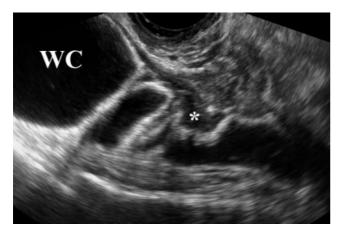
Rectal water contrast transvaginal ultrasonographic image showing a rectal endometriotic nodule thickening the muscularis mucosa (asterisk). The rectal lumen is distended by saline solution (WC).
